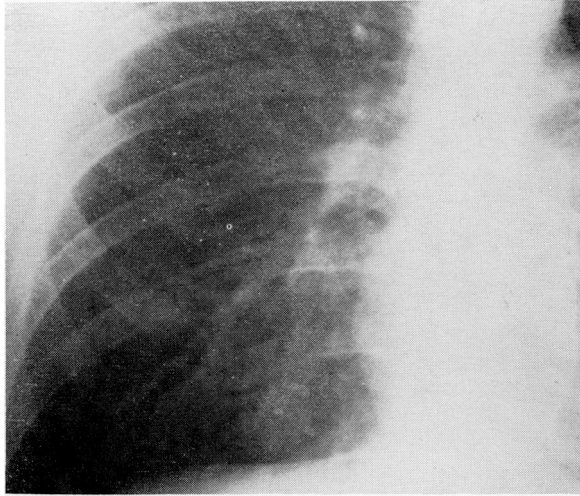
Roentgenogram, Case 1. A rounded, sharply defined shadow is visible in the right lower lobe. The spherical nodule was 2 cm. in diameter.
